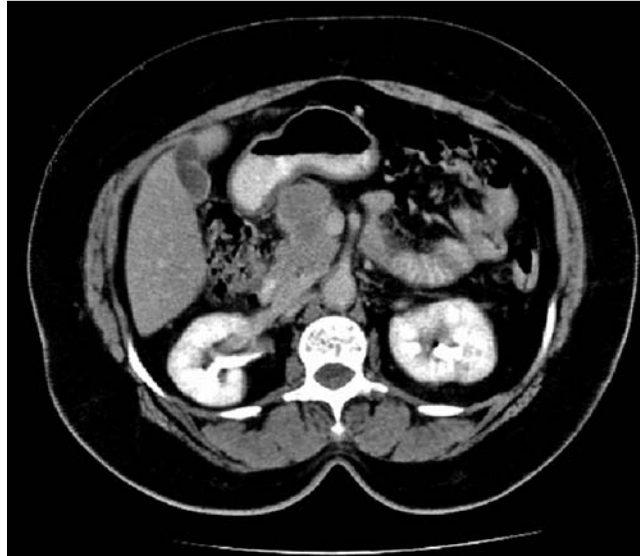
Abdominal computed tomographic (CT) scan showing a hypovascular, 35-mm pancreatic head mass.
